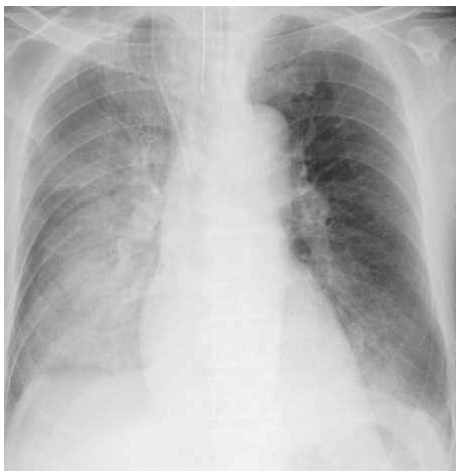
Chest X-ray indicated residue of the consolidation in both lungs on Day 11 of hospitalization, when the patient's respiratory status improved and mechanical ventilation was removed.
